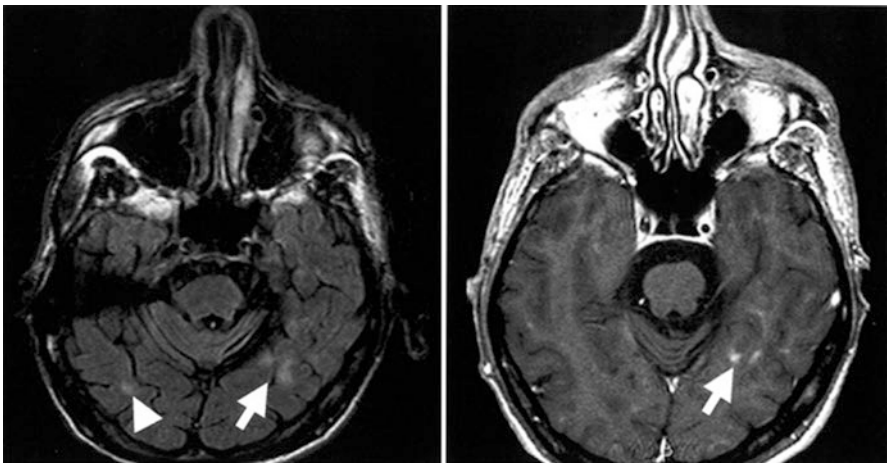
Contrast enhancement of PML lesions in a patient with IRIS. A left temporal lobe lesion seen in FLAIR (*arrow, left panel*) minimally enhances after gadolinium injection in T1-weighted image (*arrow, right panel*), whereas a right temporal lobe lesion is only detected in FLAIR sequence (*arrowhead, left panel*) [80]
